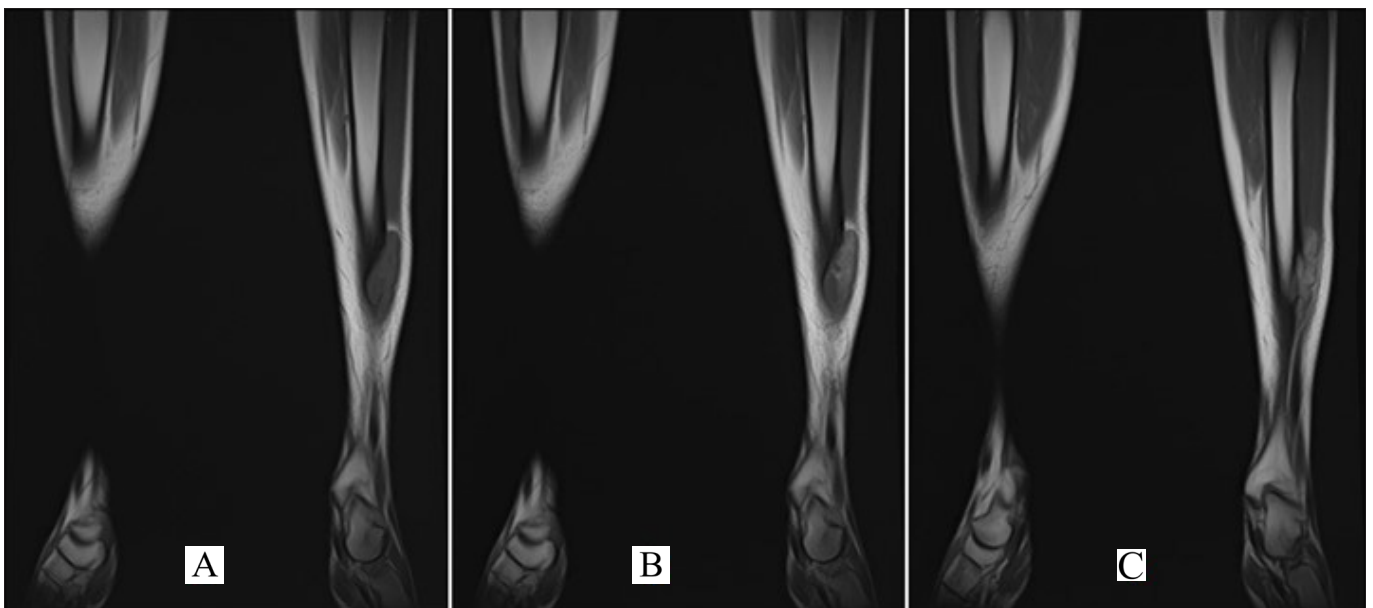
(a) Coronal T1-weighted image reveals anterior of tibia presence of tumor with intermediate signal intensity showing soft-tissue extension. (b-c) Coronal T1-weighted image obtained after administration of contrast medium shows enhancement, cortical destruction and soft-tissue extension.
